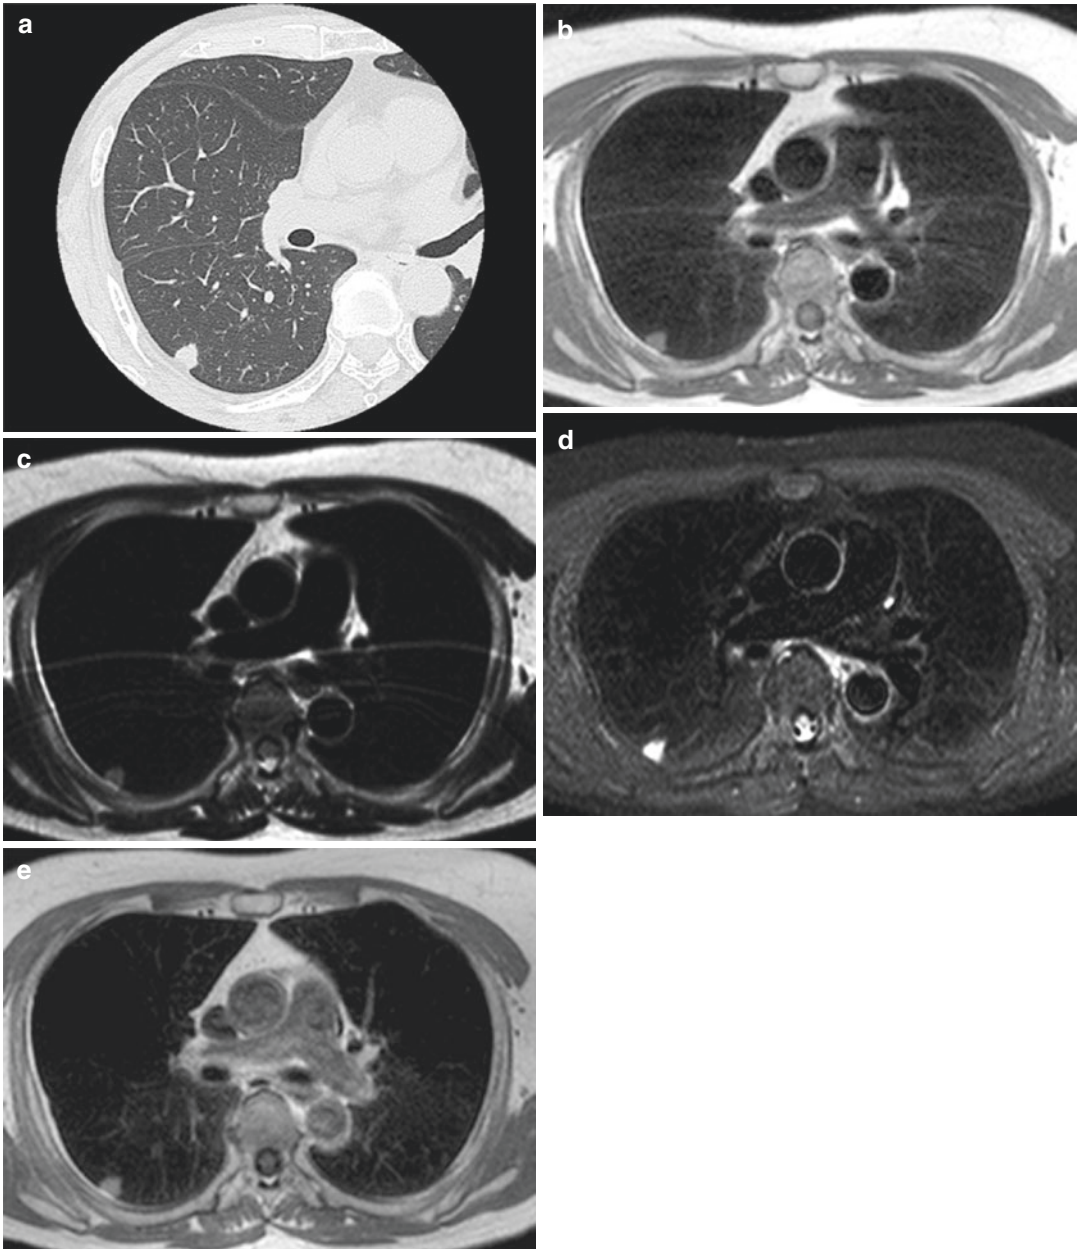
A 56-year-old female with adenocarcinoma in the right lower lobe. Thin-section CT shows a solid nodule in the right lower lobe (a). Black-blood T1-weighted turbo SE (b), T2-weighted turbo SE (c), and STIR turbo SE (d)
